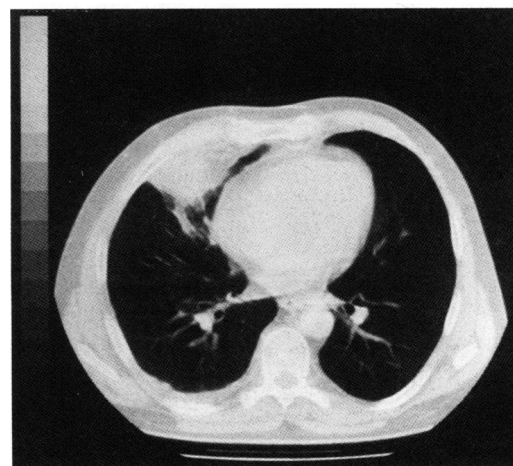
Computed tomographic scan of case 1 showing a subphrenic abscess along with infiltrative defects of the right chest wall.
